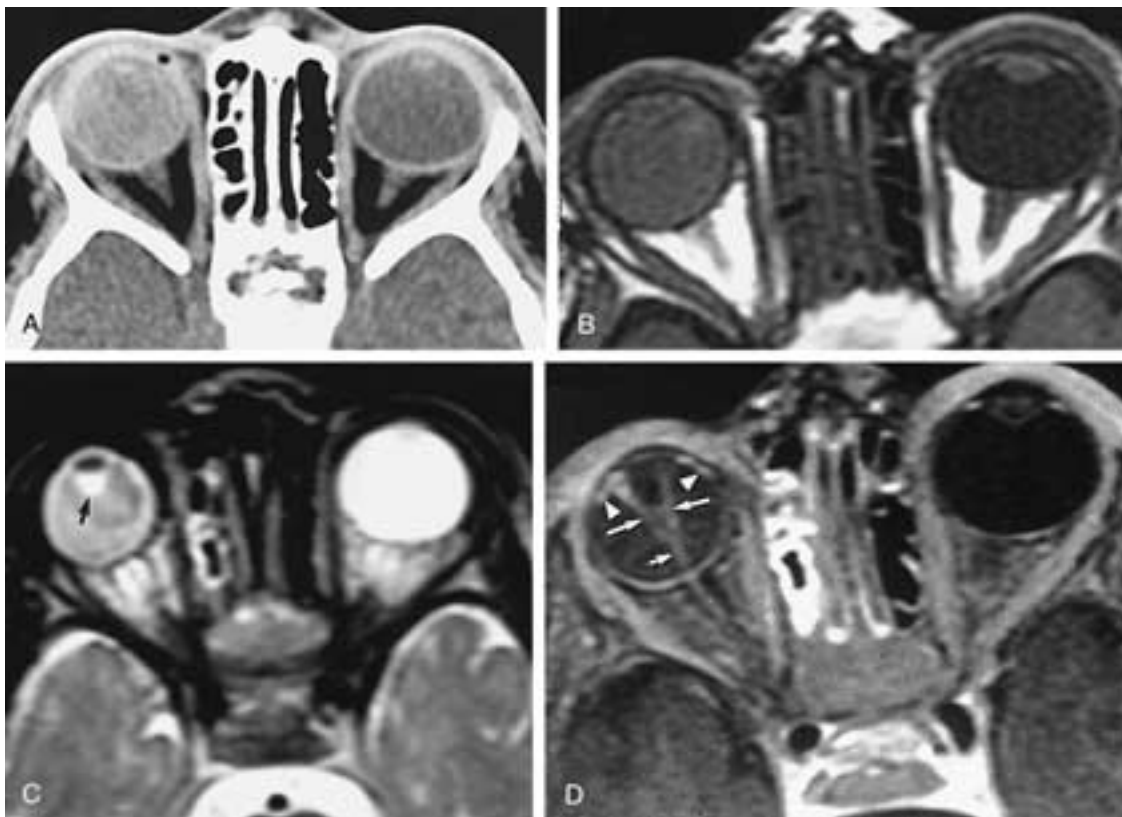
A, Axial CT scan shows the diffuse increased density of the right globe caused by total retinal detachment. A retinoblastoma cannot be excluded. B, Nonenhanced axial T1-weighted MR image shows slightly increased intensity of the right globe caused by total exudative retinal detachment. C, Axial T2-weighted MR image shows mixed signal intensities caused by a lipoproteinaceous exudate. The collapsed remaining part of the vitreous (*arrow*) appears hyperintense. D, Axial fat-suppressed, contrast-enhanced, T2-weighted MR image shows enhancement of the thickened, detached sensory retina (*arrows*). Note the enhancement of the peripheral retina (*arrowheads*) characteristically seen in Coats' disease, consistent with enhancement of telangiectatic vessels seen in F and G. A retinoblastoma can now be excluded.
